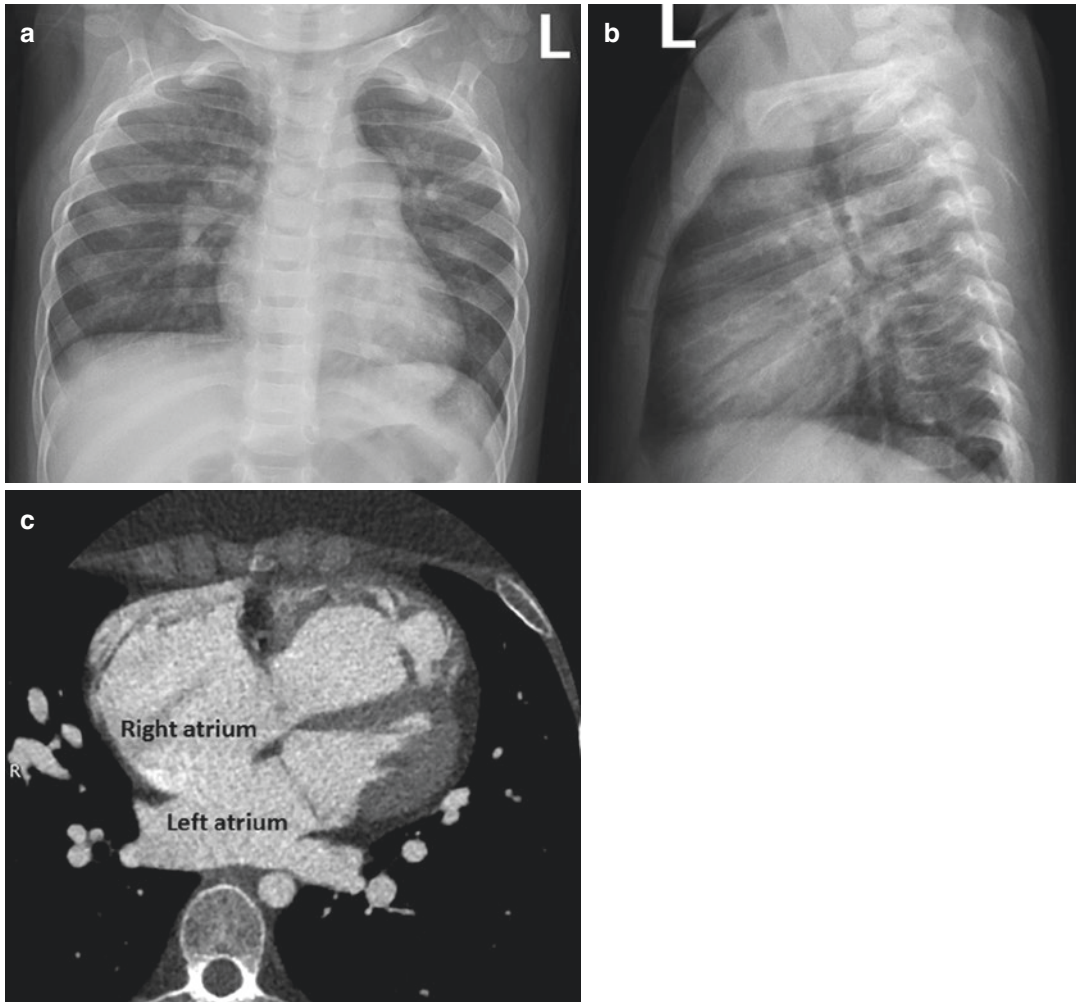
Atrial septal defect (ASD) in a 1-year-old girl with cardiac murmur for 1 month. Echocardiographic examination reveals ASD. (a and b) PA and lateral chest radiographs show increased lung markings, prominent
